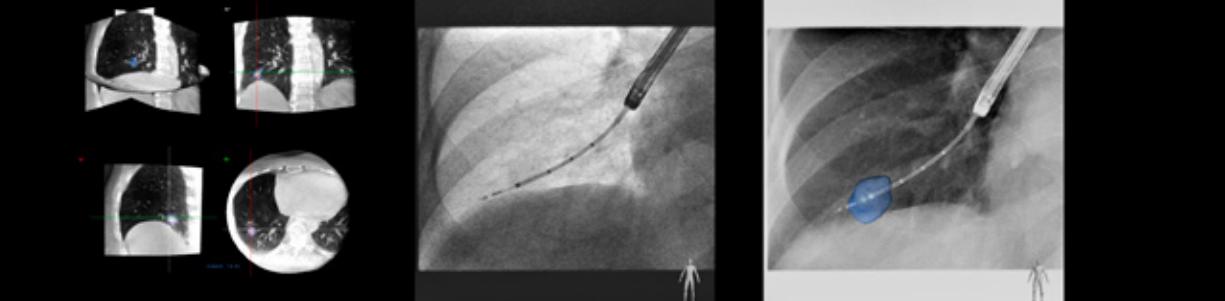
3D segmentation of CBCT dataset to highlight target nodule (left). Standard 2D live fluoroscopy versus corresponding Augmented live fluoroscopy (right).
